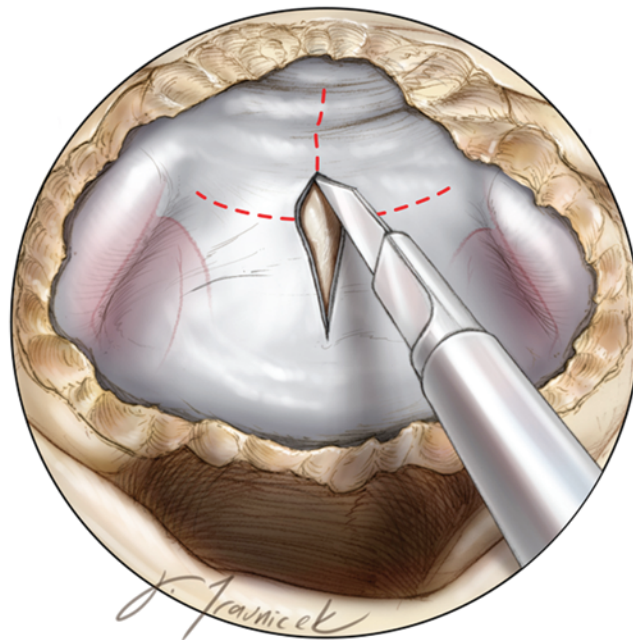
Please note that we prefer to remove bone laterally over the carotid arteries to allow more working angles laterally by gently mobilizing these vascular structures. The dura is opened over the sella in a cruciate fashion. The dural incisions may be guided by ultrasonography to avoid injury to the ICAs. From *The Neurosurgical Atlas*. Copyright Aaron Cohen-Gadol. Published with permission.
